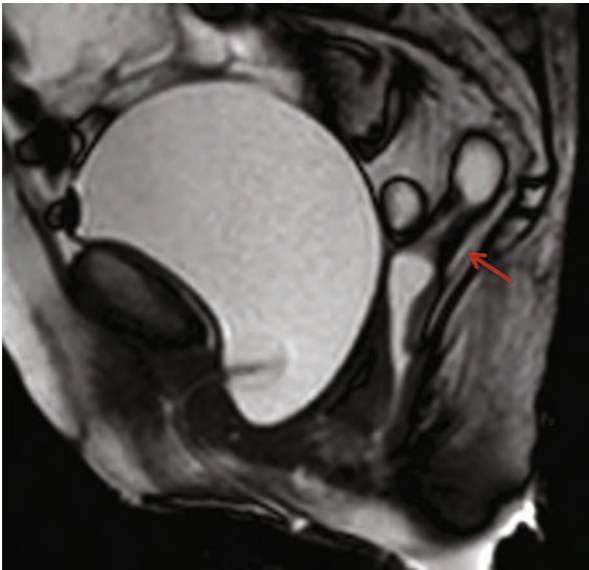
Magnetic resonance defecography performed on a 1.5 T magnet. T2-weighted balanced fast field echo sequence acquired in the voiding phase. A complete internal rectal prolapse is visible (*arrow*), involving all the layers of the wall
